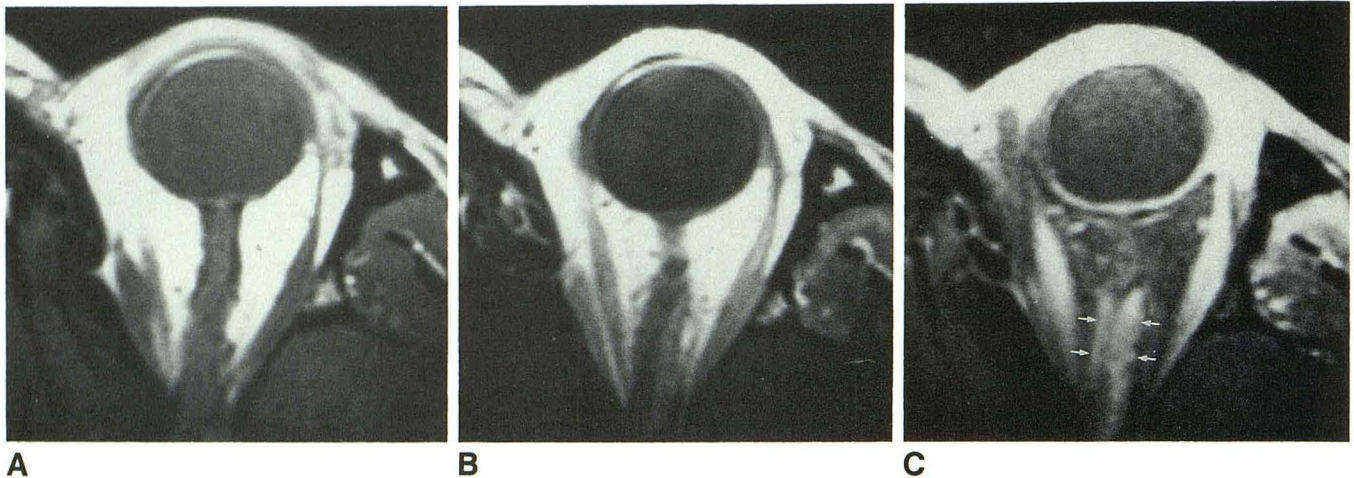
A–C, Axial T1-weighted spin-echo MR images of an optic nerve sheath meningioma before IV injection of gadopentetate dimeglumine (A), after contrast injection (B), and with fat suppression after contrast injection (C). The lesion was not appreciated in the unenhanced image (A). After IV contrast administration, a thin band of moderately enhancing tissue is seen posteriorly alongside lateral aspect of nerve (B). With fat suppression (C), tumor (arrows) is distinctly seen medial and lateral to the optic nerve. This patient was originally referred for suspected optic neuritis. A fundoscopic examination after MR imaging showed optociliary shunt vessels, and subsequent CT findings were most consistent with meningioma.
